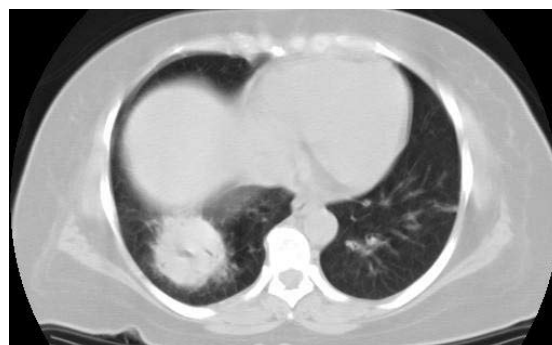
CT image of the chest shows a large nodule with cavitation.
